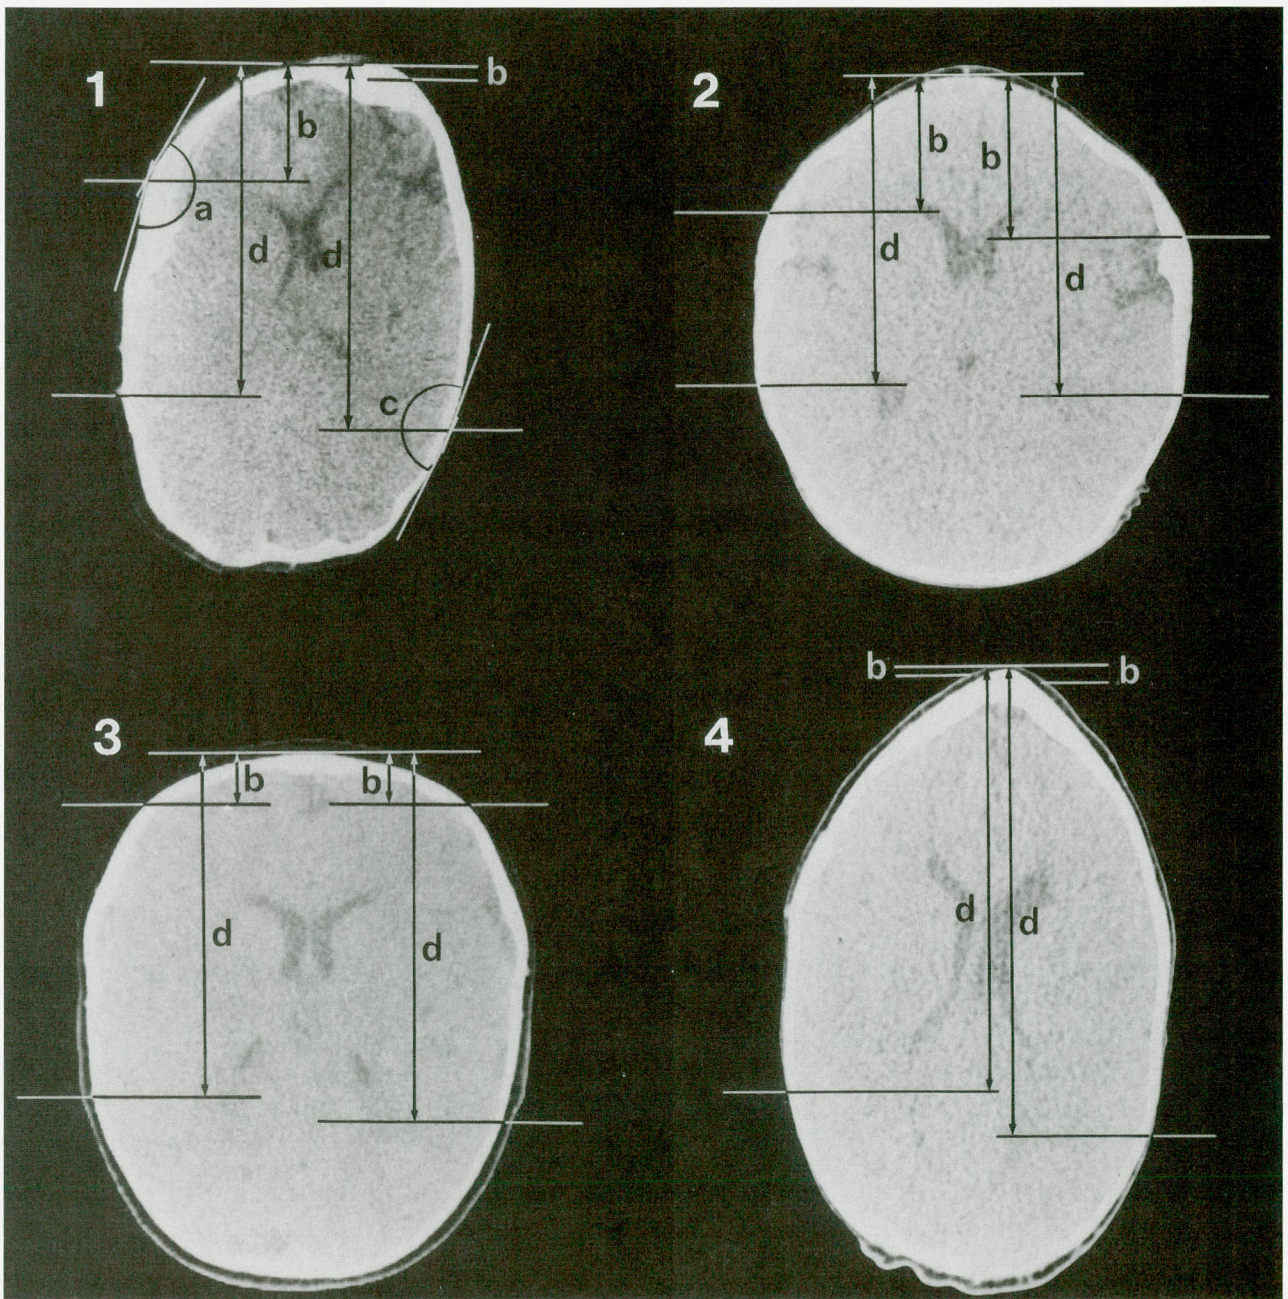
Bone center measurements from axial CT scans: (4.1) plagiocephaly; (4.2) Apert; (4.3) Crouzon; (4.4) trigonocephaly. (a) Frontal bone center angle; (b) frontal bone center distance; (c) parietal bone center angle; (d) parietal bone center distance.
